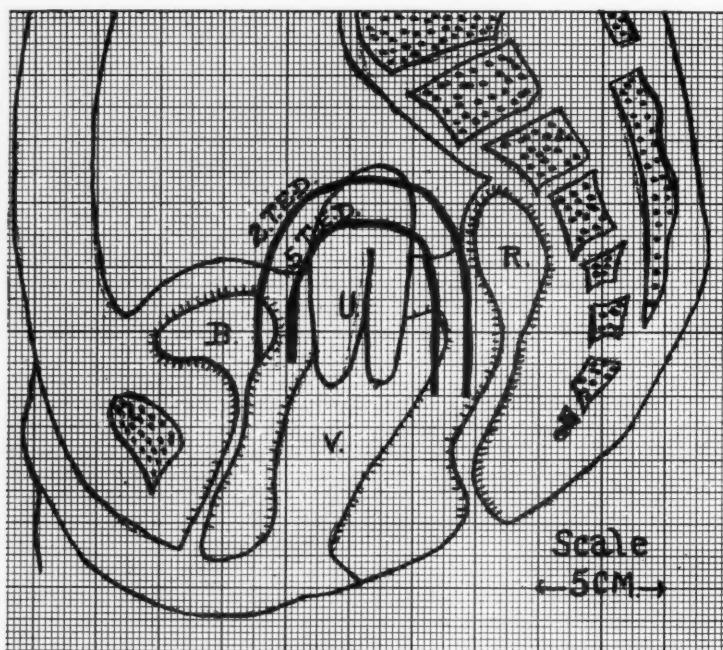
Distribution of pervainginal roentgen radiation. Median sagittal section.
